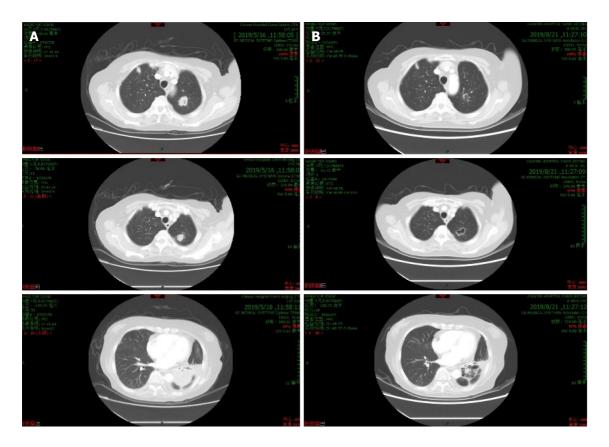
Changes in lung lesions after nab-paclitaxel plus apatinib treatment. A: Computed tomography (CT) before treatment (baseline); B: CT scans after 6 cycles of nab-paclitaxel plus apatinib.
